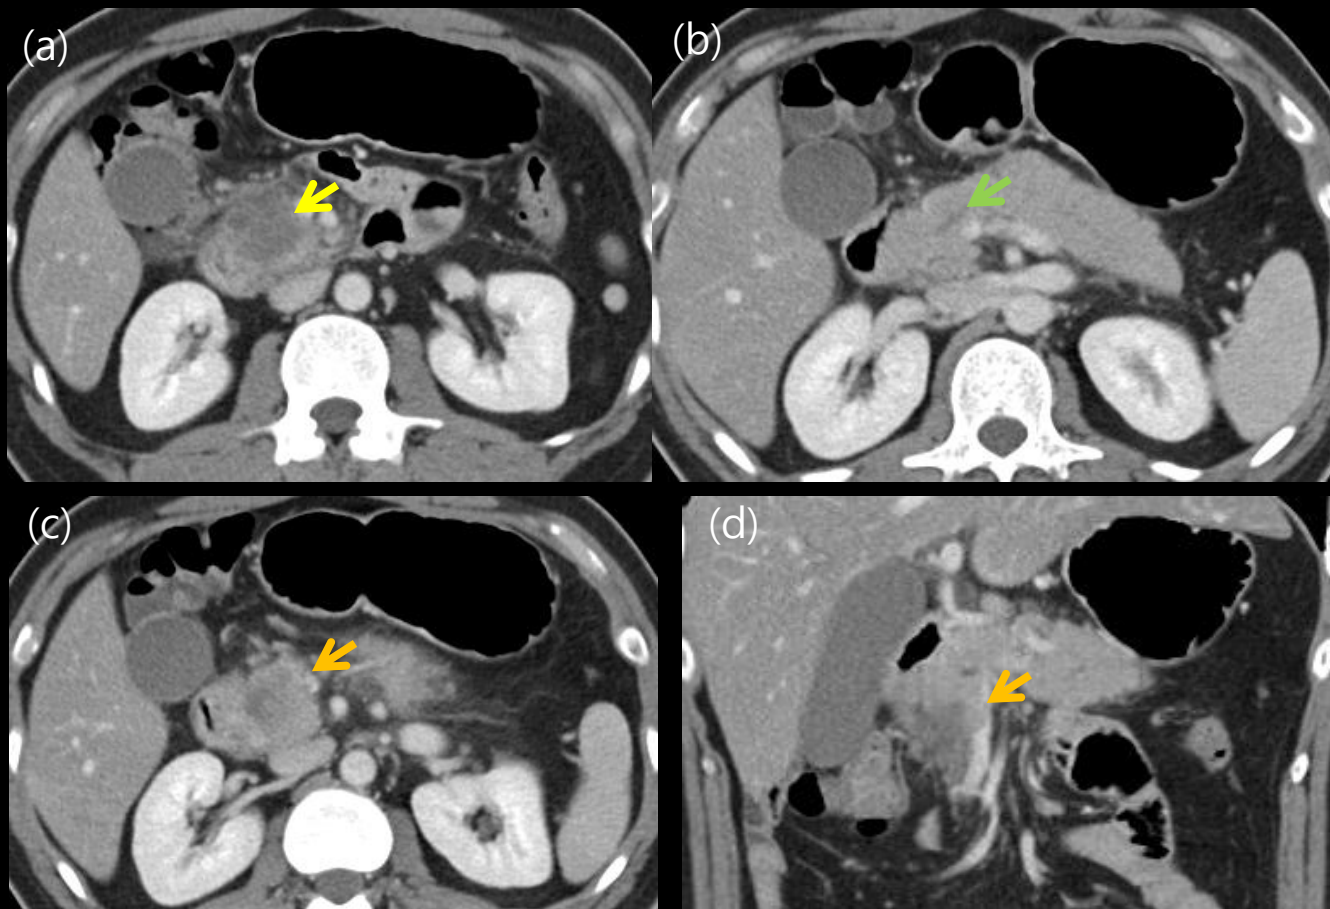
31 years old man presented with acute pancreatitis by pancreatic adenocarcinoma. (a), (b) Axial contrast material–enhanced abdomen CT images shows diffuse pancreatic swelling without peripancreatic infiltration, fluid collection and heterogeneous ill-defined round hypodense lesion (yellow arrow) in pancreatic head with mildly dilated pancreatic duct. (green arrow)
